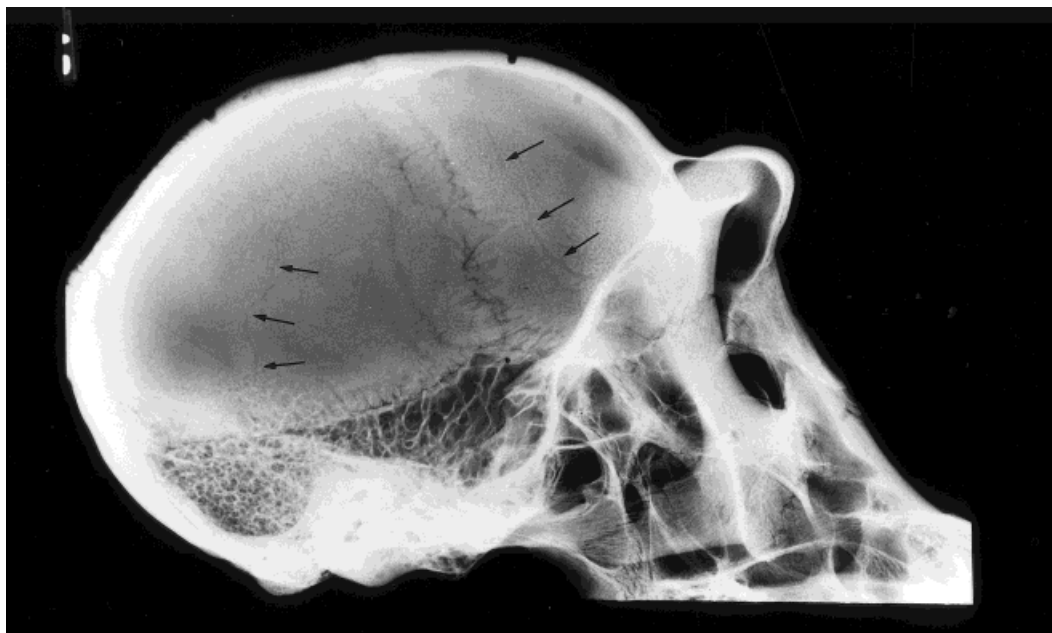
Lateral x-ray view of a chimpanzee skull. Note the small, narrow diploic veins (arrows) in both parietal and frontal bone.
